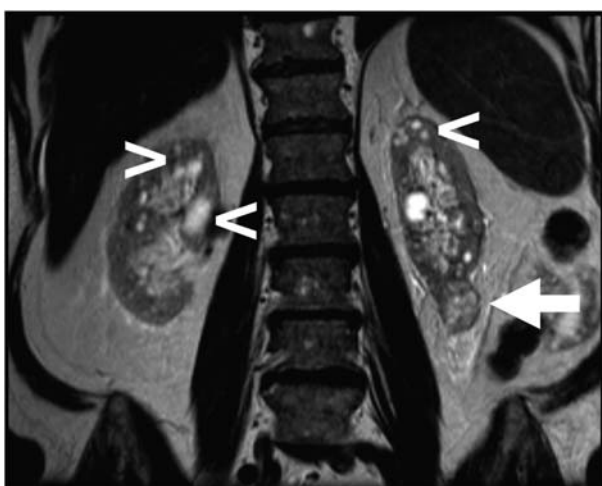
Typical MRI of a CD tumour in a patient on chronic lithium therapy. A large tumour can be seen in lower pole of the left kidney (arrow). In addition, numerous renal cysts are present in both kidneys (open arrows).
